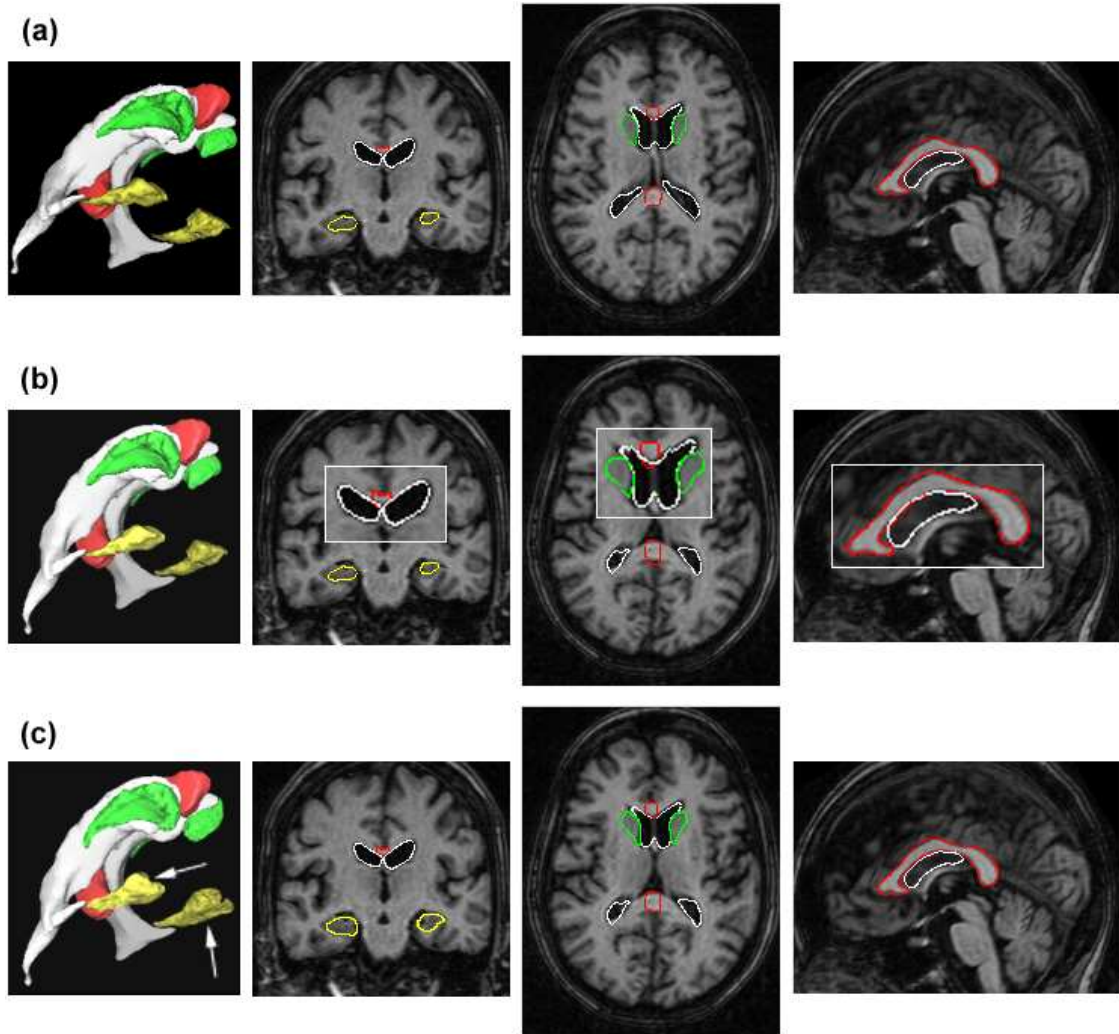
Segmented target structures (in color) in a typical T1-weighted MRI: (a) with the complete segmentation system (all rules, all constraints); (b) without distance constraints (white rectangles shows magnified portions of the MRI where templates intersect); (c) without shape constraints (white arrows point to topological alterations of the hippocampi).
